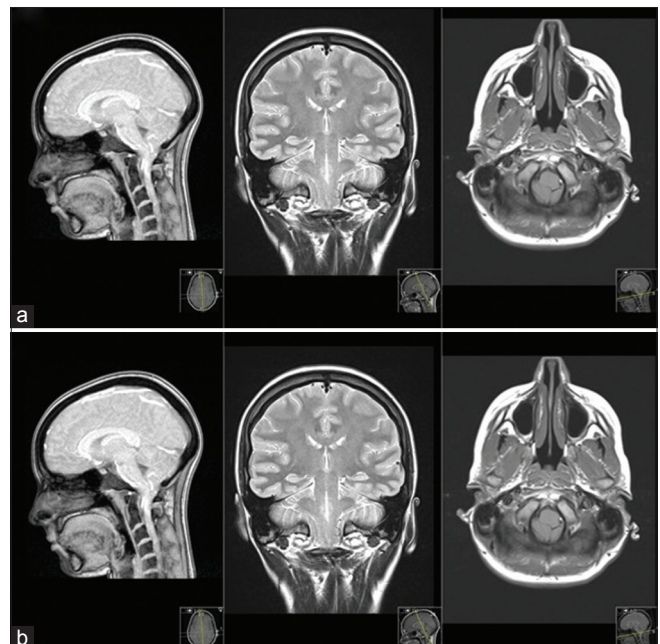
Initial (a) and follow-up (b) magnetic resonance imaging demonstrating CMI. (a) First magnetic resonance imaging November 2016. (b) Second and f/u magnetic resonance imaging January 2018, no change in Chiari malformation, tonsillar herniation, or foramen magnum compression however with dramatic clinical improvement
